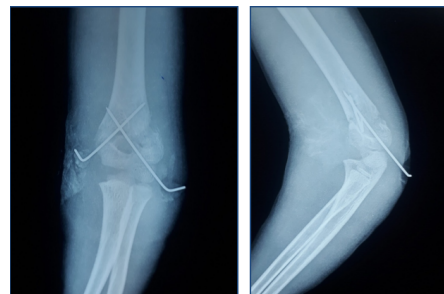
Showing post operative x-rays of closed reduction and crossed pinning in both AP and Lat views
